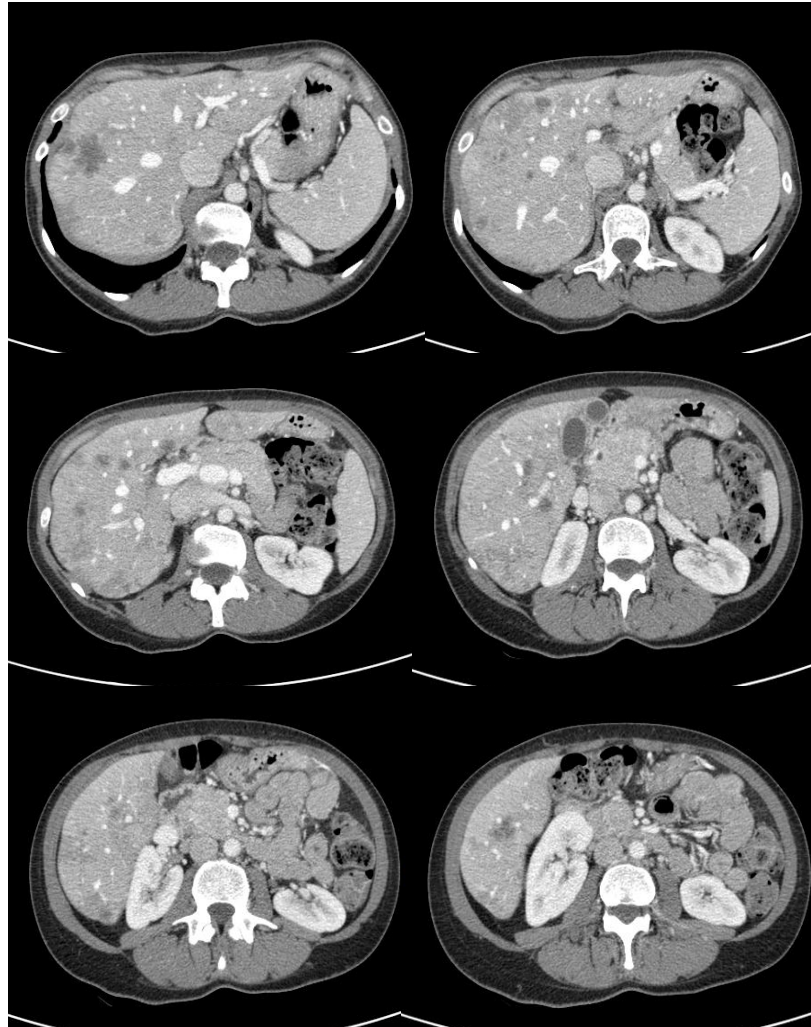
CT-scan at diagnosis
